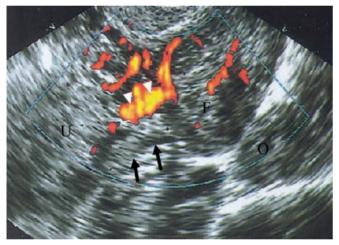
Transvaginal US of pedunculated fibroma. The use of the power Doppler technique allows identification of vessels (*arrowheads*) within the pedicle (*arrows*) running from the uterus (*U*) to the fibroma (*F*). *O* ovary
